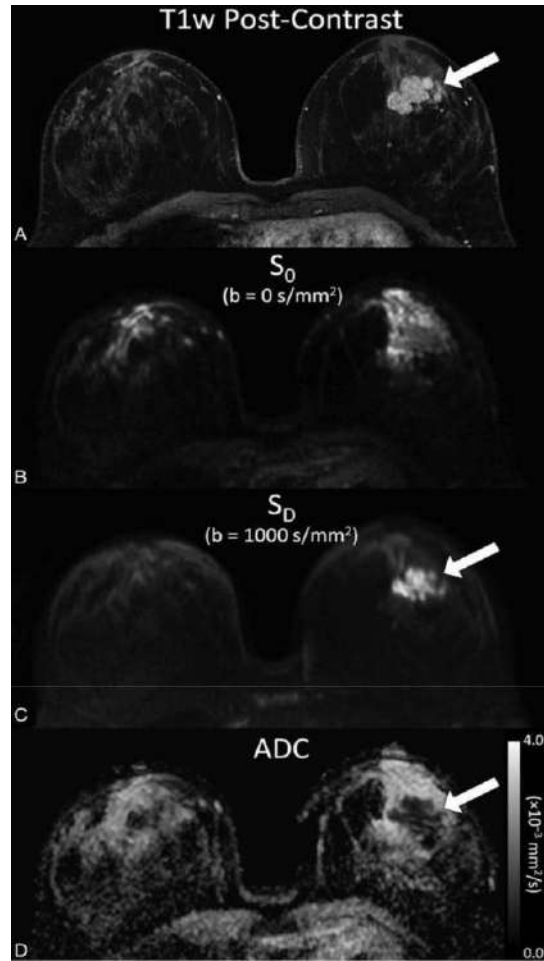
Example breast DWI images obtained in a 37-year-old woman with invasive breast cancer. Shown are corresponding images from (A) post-contrast T1-weighted image, (B) DWI S_0 with $b = 0 s/mm^2$, (C) DWI S_D with $b = 1000 s/mm^2$, (D) apparent diffusion coefficient (ADC) map. Invasive carcinoma (arrow) exhibits reduced diffusivity on DWI, appearing hyperintense on the S_D image and hypointense on the ADC map. [4]
